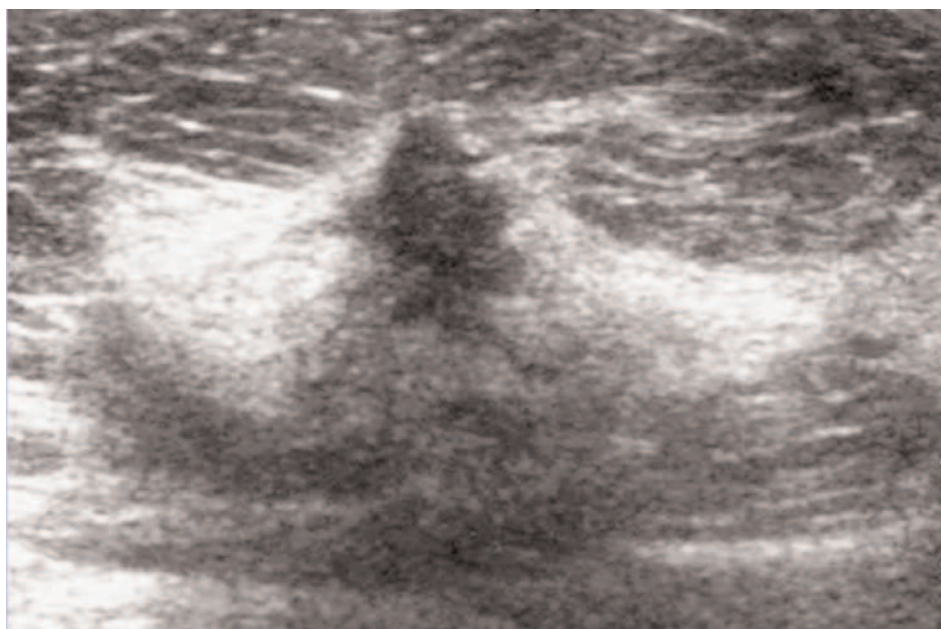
Invasive ductal carcinoma with malignant sonographic characteristics.
